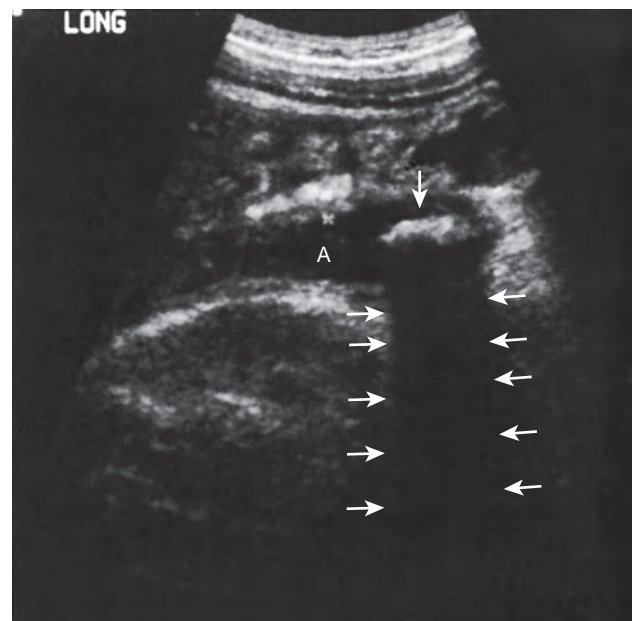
Sonogram of an inflamed appendix containing an appendicolith. Longitudinal image shows a thick-walled, fluid-filled appendix (A). The layers of the appendiceal wall are not well defined. An appendicolith (large arrow) is identified as an echogenic focus with acoustic shadowing (small arrows).
